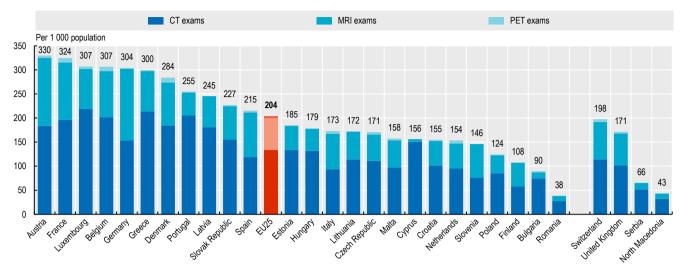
CT, MRI and PET exams per 1 000 population, 2018 (or nearest year)
